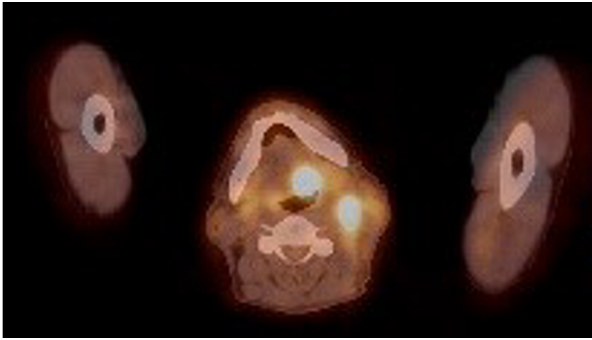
Lesion on the posterior segment of the left lateral tongue and cervical lymph nodes on PET-CT.
